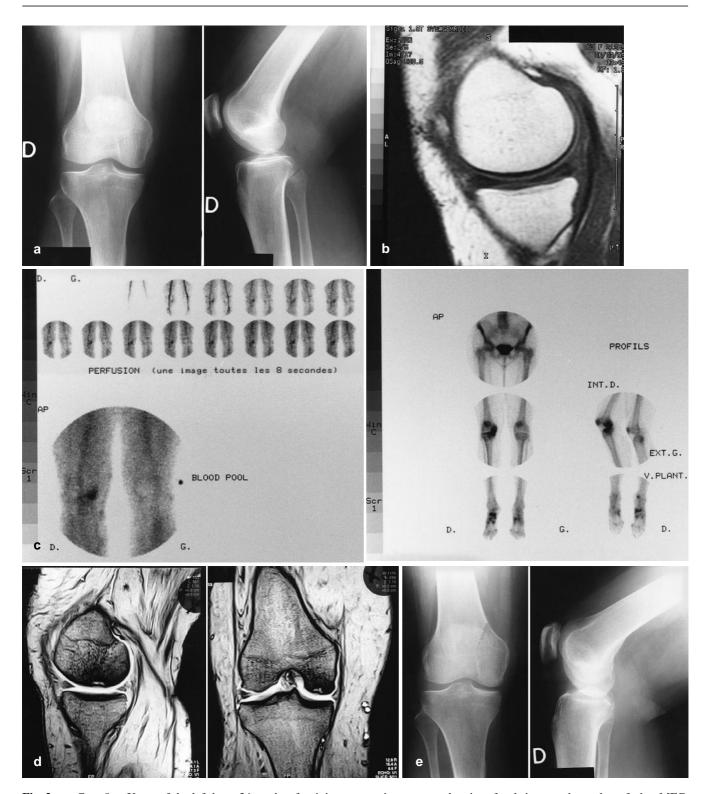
Case 8. a X-ray of the left knee 34 weeks after injury. b MRI 36 weeks after injury. Grade III tear of the posterior horn of the medial meniscus. c Bone scan 26 weeks after arthroscopic
